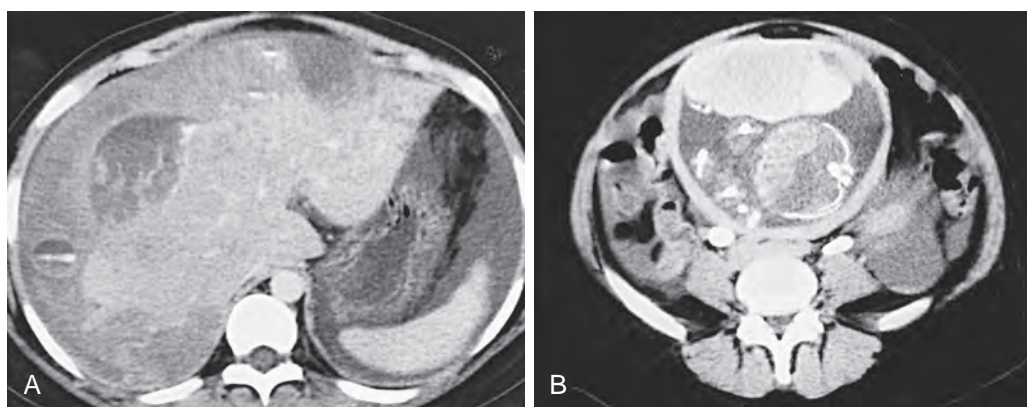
HELLP syndrome. This pregnant patient presented with acute abdominal pain, hemolysis, elevated liver enzymes, and low platelets (HELLP). A. CT scan shows hepatic hemorrhage with active extravasation of contrast material from multiple sites. Hypodense areas are also present, suggesting thrombosis. B. CT scan obtained at a lower level shows the fetus.
